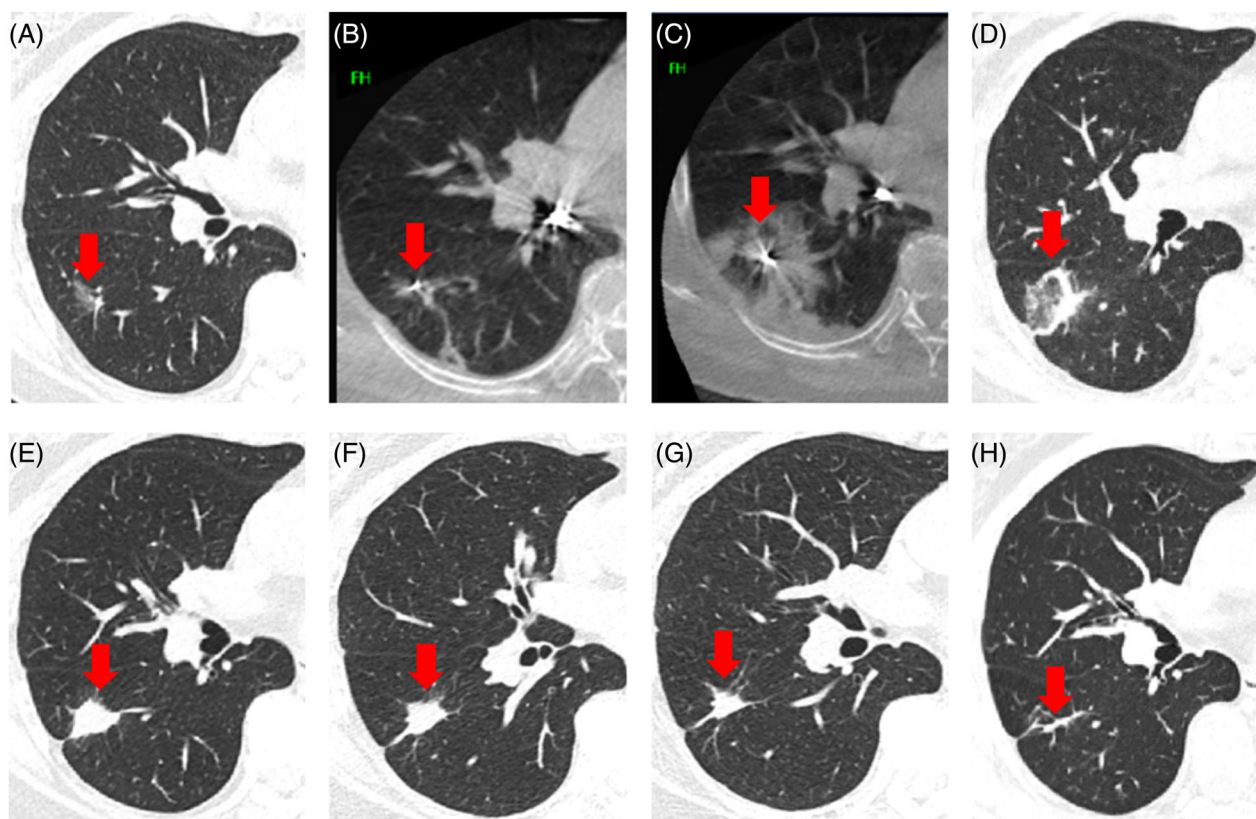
CT images acquired for preoperative evaluation and of the surgical procedure. (A): CT images acquired for preoperative evaluation. Red arrow: Target lesion. (B): Cone-beam CT images of intraoperative electrode positioning. Red arrow: Target lesion and RFA electrode. (C): Cone-beam CT images acquired immediately after ablation. Red arrow: Target ablation zone. (D–H): CT images acquired at 24 h, 1 month, 3 months, 6 months, 12 months. Red arrow: Target ablation zone.
